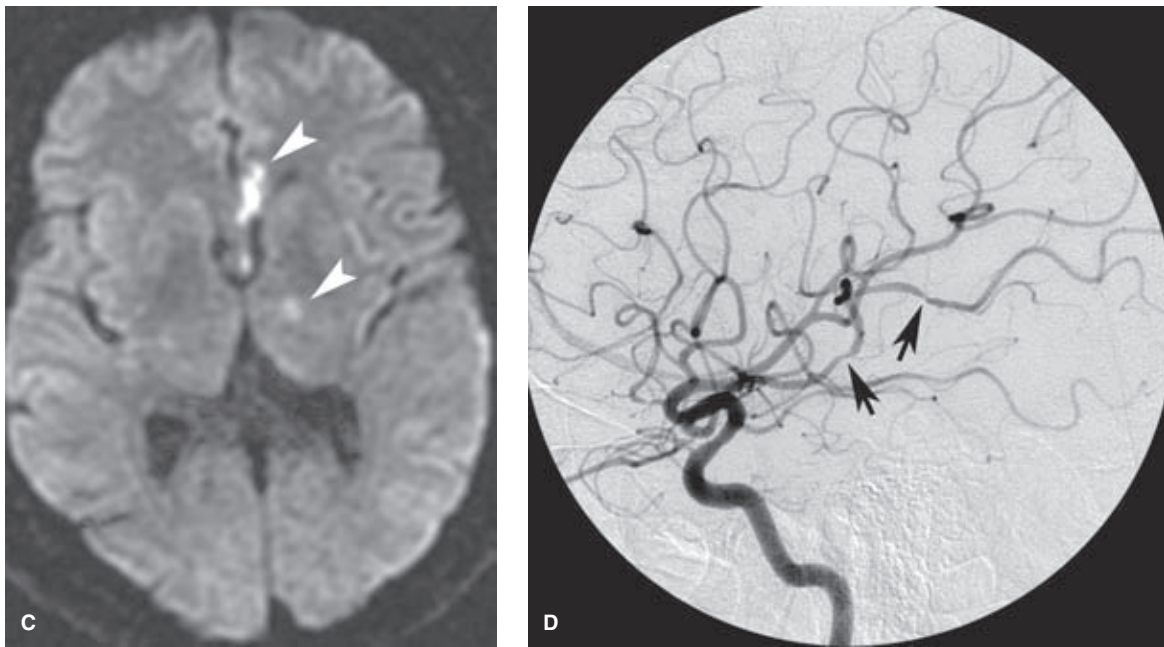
(CONTINUED) Other infarcts (*arrowheads* in B, T2 MRI, and C, DWI scan) are seen in the forebrain and thalamus. A cerebral angiogram of the left internal carotid artery (D) shows that the angiographic confirmation of vasculitis (*arrows*) can be relatively subtle, even when other manifestations of the disease are florid.
